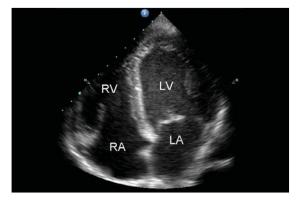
Normal apical four-chamber view. RV, right ventrical; LV, left ventricle; RA, right atrium; LA, left atrium. (Reproduced, with permission, from Carmody KA, et al: Handbook of Critical Care and Emergency Ultrasound. McGraw-Hill, 2011.)
